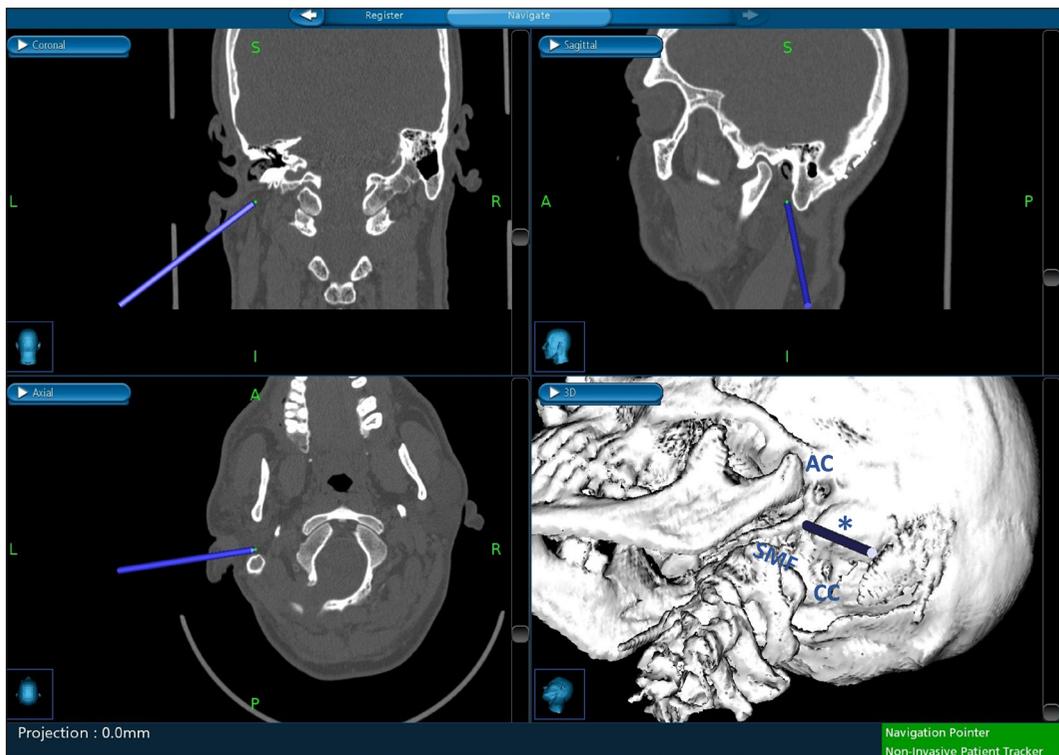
Precise identification of the stylomastoid foramen (SMF) with magnetic computed tomography (CT)-based neuronavigation (StealthStation, Medtronic); acoustic canal (AC), condyloid canal (CC) and mastoid tip (asterisk) are also recognizable.
